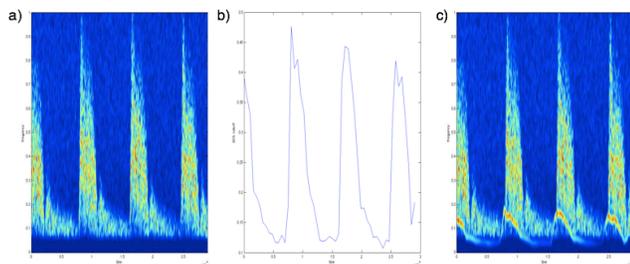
Spectrogram of unstained Doppler audio recording (4.a), plot of the calculated 80% rolloff values over time for the same recording (4.b), and spectrogram of the original recording with a sine tone added as described above (4.c). Time is shown in samples, frequency and rolloff are shown as a fraction of the Nyquist frequency of 5000 Hz.
